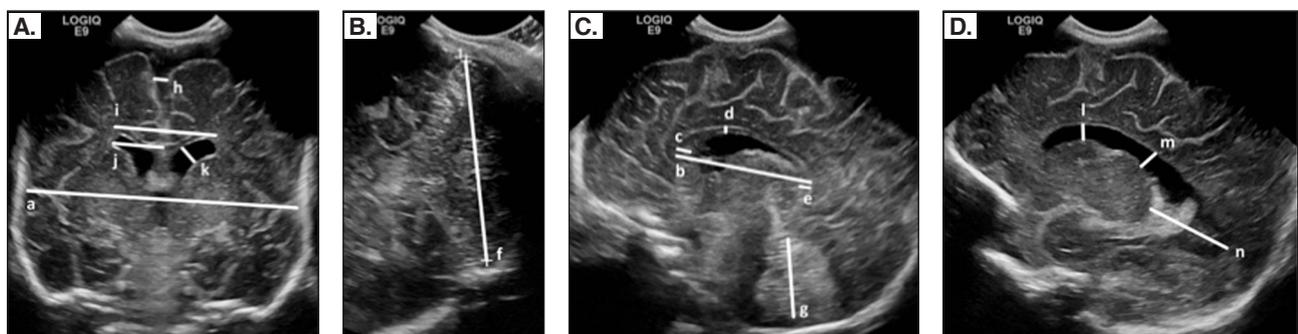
(ABS 86). Cranial ultrasonography linear measures (images through the anterior fontanelle in the coronal plane at the level of foramina of Monroe [A] and the sagittal [C] and para-sagittal [D] planes, and image through the mastoid fontanelle in the coronal plane posterior to the fourth ventricle [B]).
